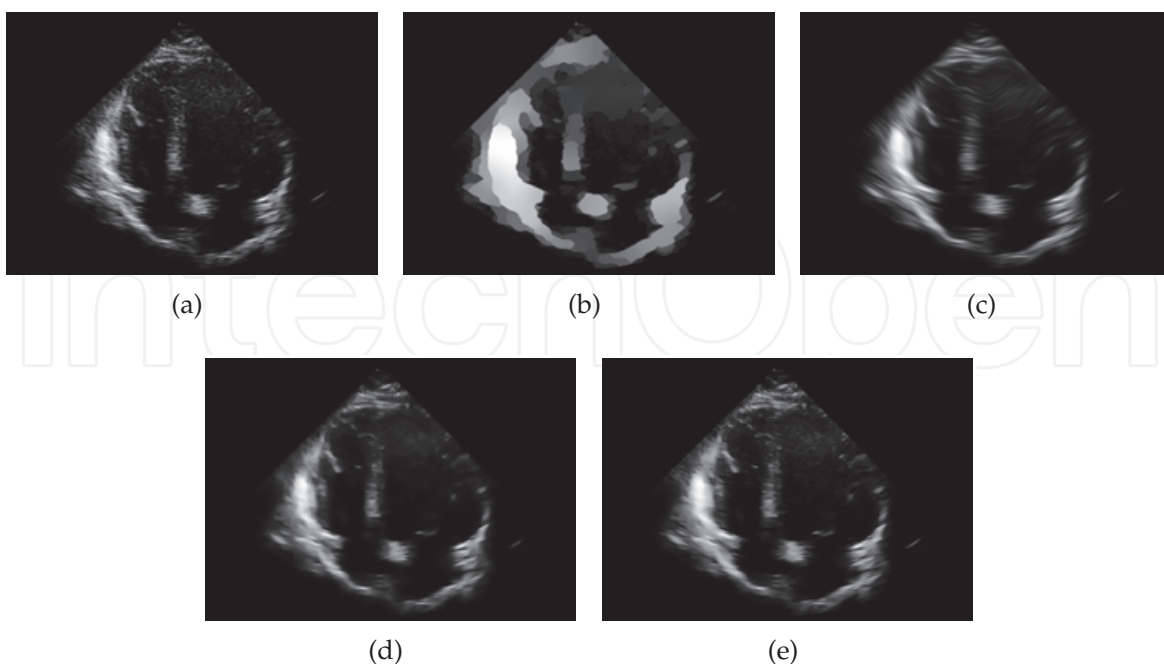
Example frame from an echocardiographic video, from the long axis view. (a) Unfiltered, (b) SRAD, (c) NCD, (d) GLM, (e) NMWD.
